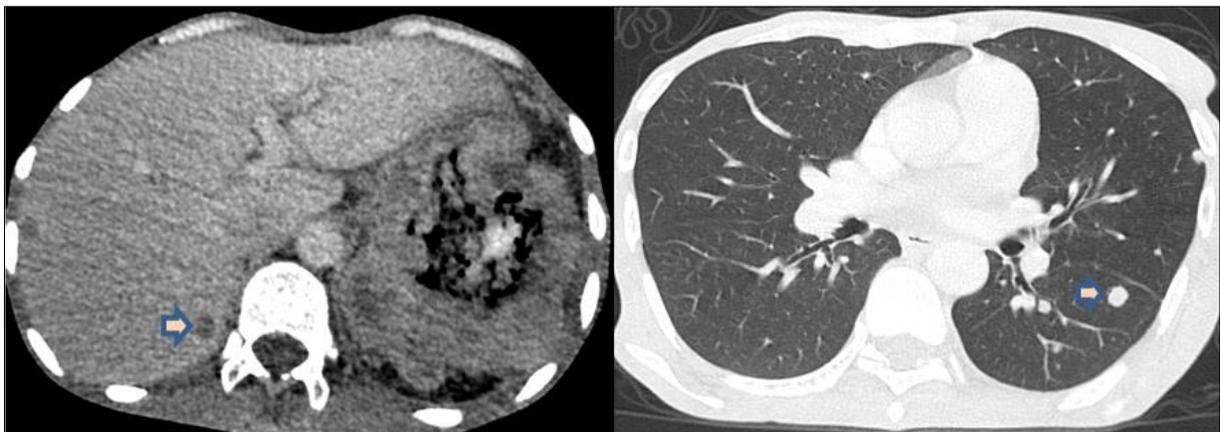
Abdomen and Thoracic CT
